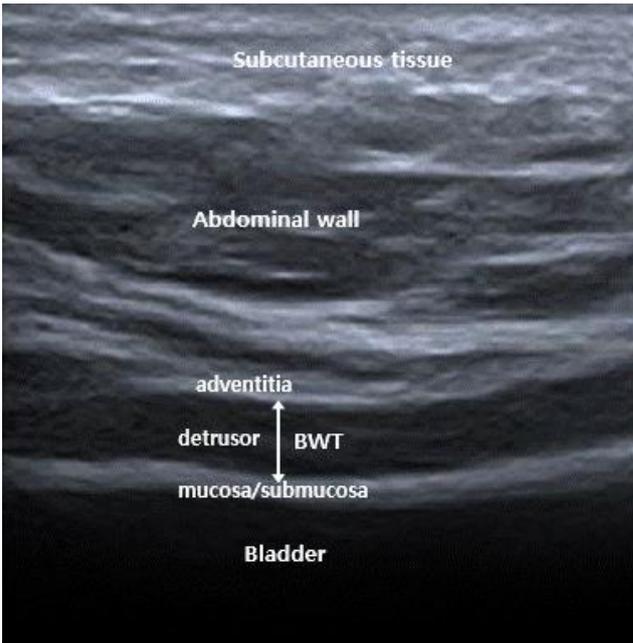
Ultrasonographic measurement of BWT of the anterior bladder wall
